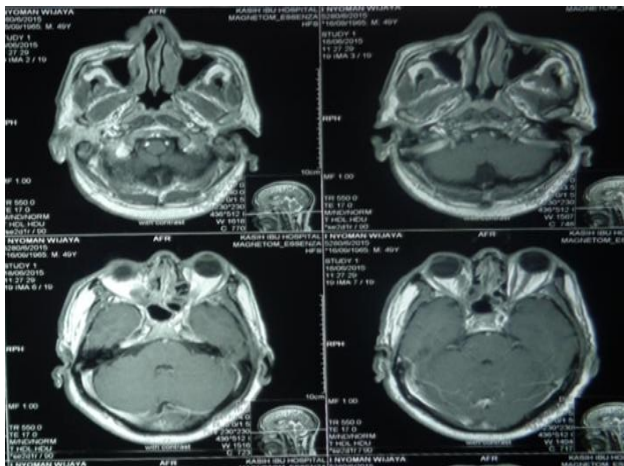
Head MRI showed atrophy of medial recti
